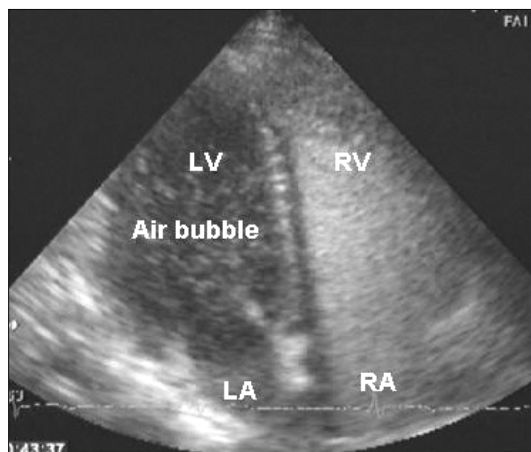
Saline contrast echocardiogram show right-to-left shunt through patent foramen ovale. The air bubbles were showed at the left atrium and ventricle.
